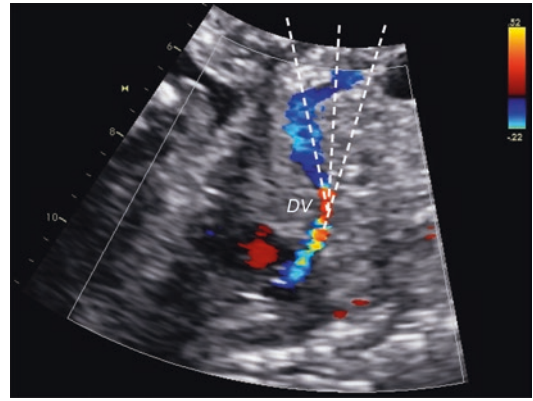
Anterior sagittal color Doppler imaging through the lower abdomen to optimize the pulsed Doppler recording. The isthmus inlet of the ductus venosus (DV) is recognized with its high velocity coding. This approach is advantageous as no ribs or pelvic bone blocks the visualization, unless small parts are positioned in front of the abdomen. The preferred interrogation for Doppler recording (interrupted lines) aims at full alignment with the flow direction and should need no angle correction. A liberal sample volume ensures that the maximum velocity along the curvature is included in the recording
